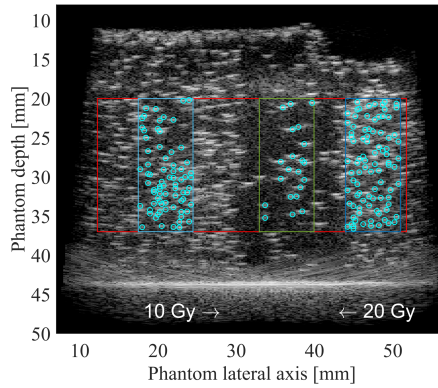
Delineation of regions of interest in the two irradiated regions and in the zone distal to both Bragg peaks, on a post-irradiation ultrasound image. The round markers indicate bubble counts. The vaporization profiles across the image lateral axis are computed over the red region of interest.
